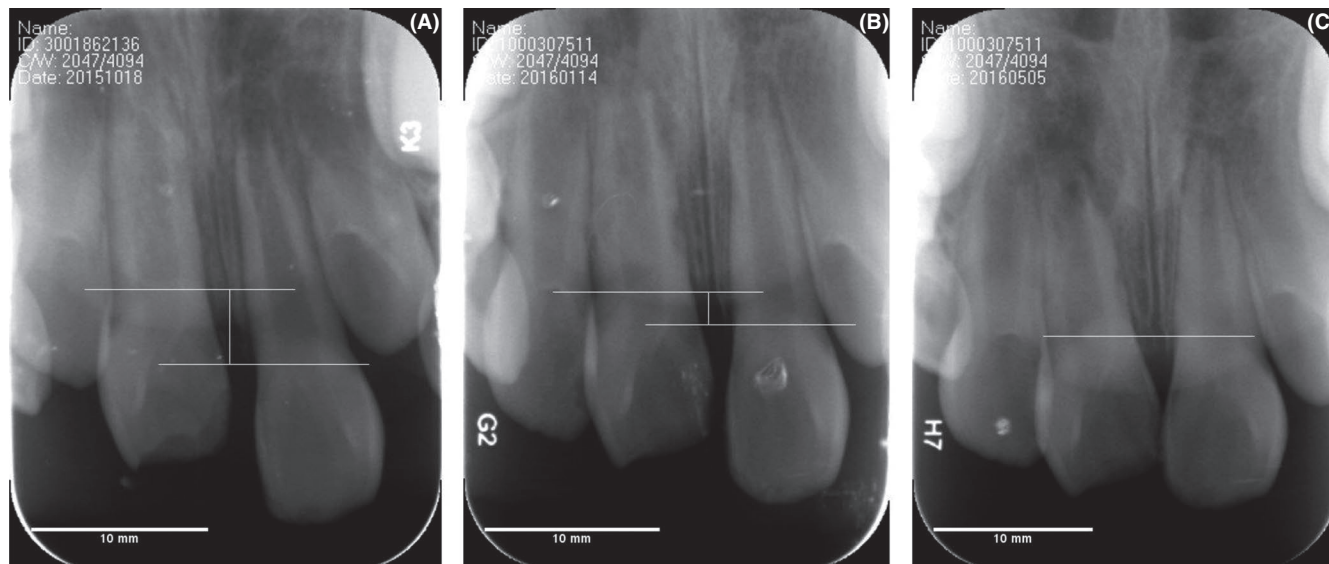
Intrusion and spontaneous re-eruption process of an immature upper right central incisor. A, Measurement of intrusion depth. The degree of intrusion was measured to the nearest millimetre on the radiograph as the difference in the level of the cemento-enamel junction in the intruded tooth and the corresponding contralateral tooth. B, Three months later, the intruded tooth partially re-erupted to the level of the control. C, Six and a half months after injury, the intruded tooth had completely re-erupted to the level of the control. Periapical radiolucency and inflammatory resorption were apparent
